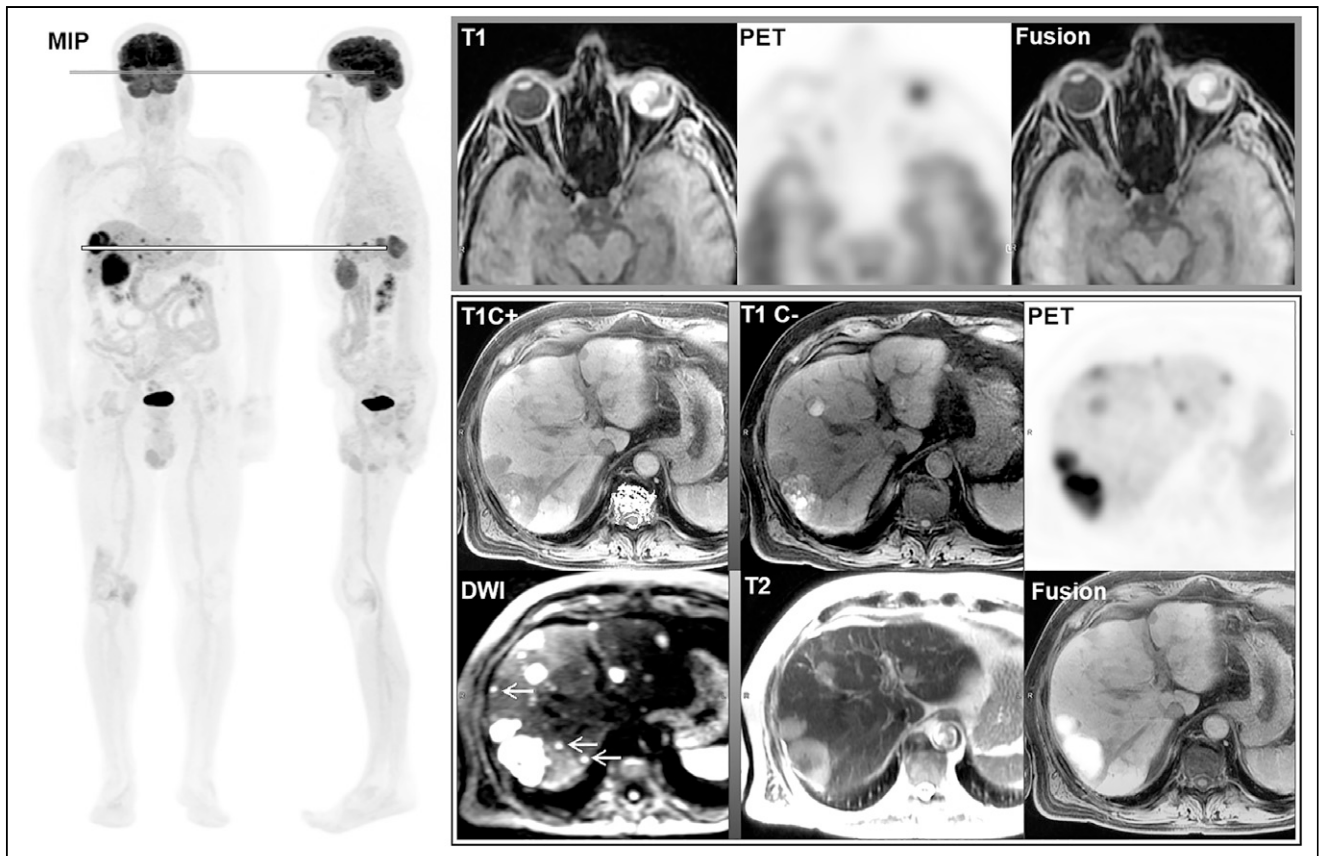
Whole-body ^{18}F -FDG PET/MRI study in surveillance of UM (case 1). Whole-body maximal-intensity-projection (MIP) images exhibit tracer-avid left eye lesion and numerous tracer-avid lesions in liver. Axial ^{18}F -FDG PET/MRI of left eye demonstrates high T1-signal lesion in left globe with increased tracer uptake, with SUV_{max} of 8.3 (top line on MIP image; top row of images). On representative layer of liver (bottom line on MIP image; bottom 2 rows of images), multiple liver lesions with variable low and high T1 signals show increased uptake, with SUV_{max} of 4.0–11.7. In addition, diffusion-weighted imaging (DWI) shows more small metastases with restricted diffusion (arrows) than does contrast-enhanced T1-weighted MRI (T1C+) or PET. T1C- = non-contrast-enhanced T1-weighted MRI; T2 = T2-weighted MRI. Color version of this figure is available as supplemental file at <http://tech.snmjournals.org>.
